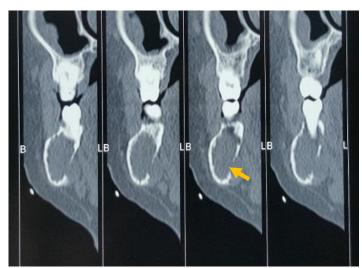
CT-scan panoramic view showing the dimension of the lesion with involvement of the IAN
